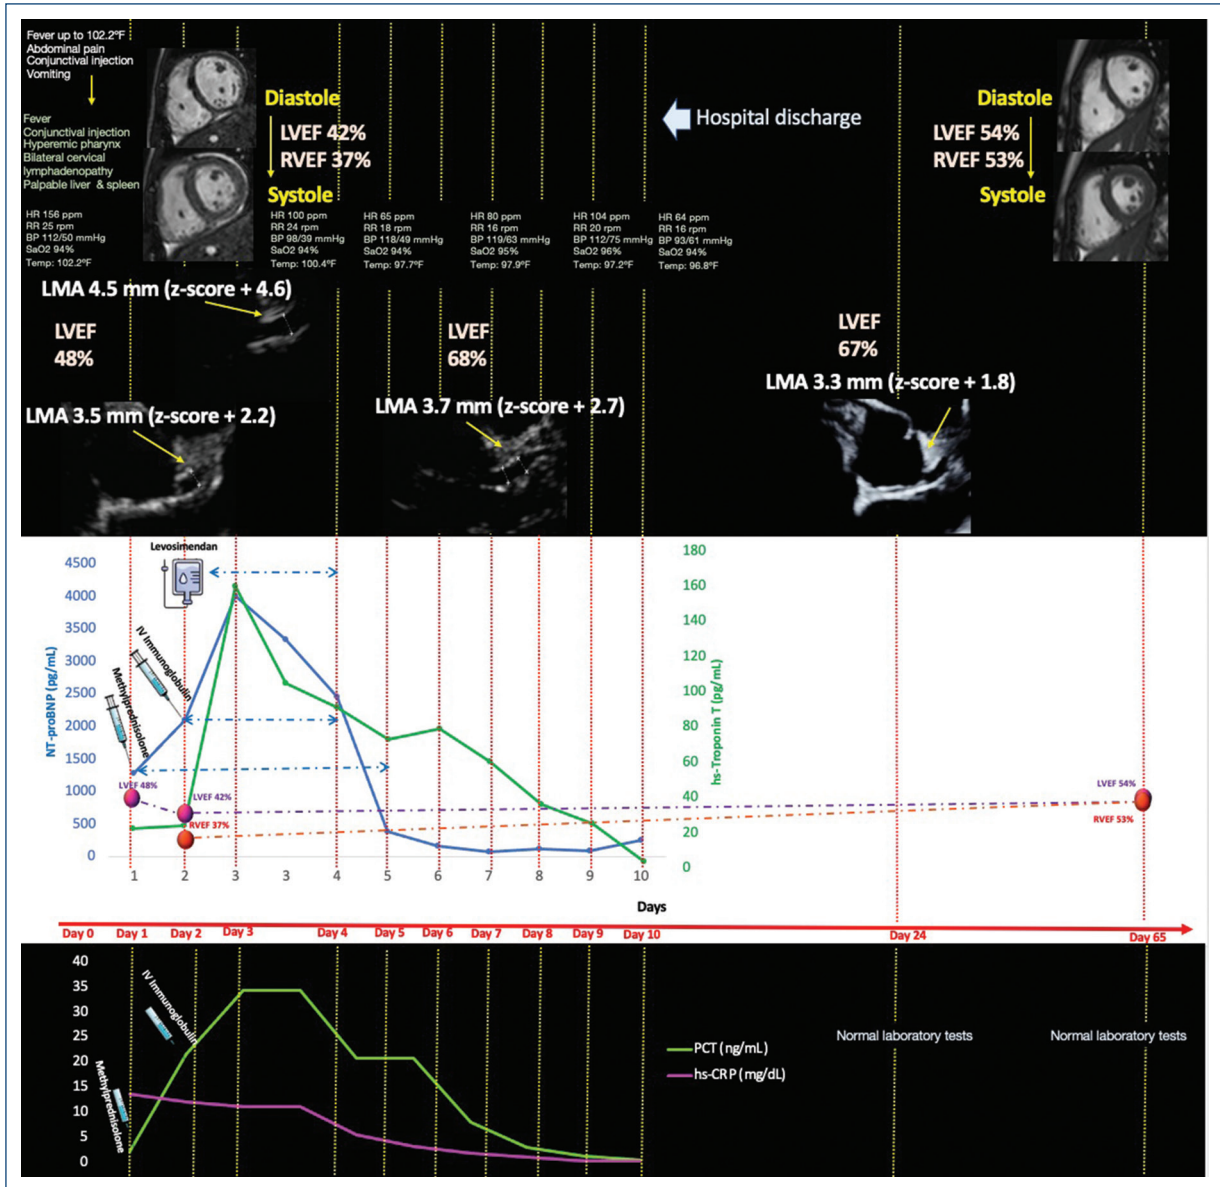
Timeline of the clinical course of the disease and its follow-up. This image represents a timeline of clinical signs and symptoms, vital signs, inflammation, cardiac dysfunction and damage laboratory tests, echocardiographic measurements of LVEF% and left main coronary artery size, and cardiac magnetic resonance measurements of left and right ventricular ejection fraction with the corresponding images of end-diastolic and end-systolic short-axis frames. The moment when the methylprednisolone, IV immunoglobulin, and levosimendan were administered. A red arrow in the middle of the image represents the timeline of the patient's evolution from the development of the first clinical manifestations through day 65 when the control CMR was performed. The days are marked in red next to the arrow, from day 0 to day 10 during his hospitalization until discharge from the hospital, then the days 24 and 65 of follow-up. Across the entire image (in red where the background is white and in yellow where it is black), the thin dashed lines mark and divide the days described in the timeline. According to the timeframe within the dashed lines, all clinical events, laboratory tests, and imaging findings are located in the corresponding moment. IV: intravenous; LVEF%: left ventricular ejection fraction; RVEF%: right ventricular ejection fraction; LMA: left main coronary artery; hs-Troponin T: high-sensitive Troponin T; PCT: procalcitonin; hs-CRP: high-sensitive C-reactive protein; CMR: cardiovascular magnetic resonance.
